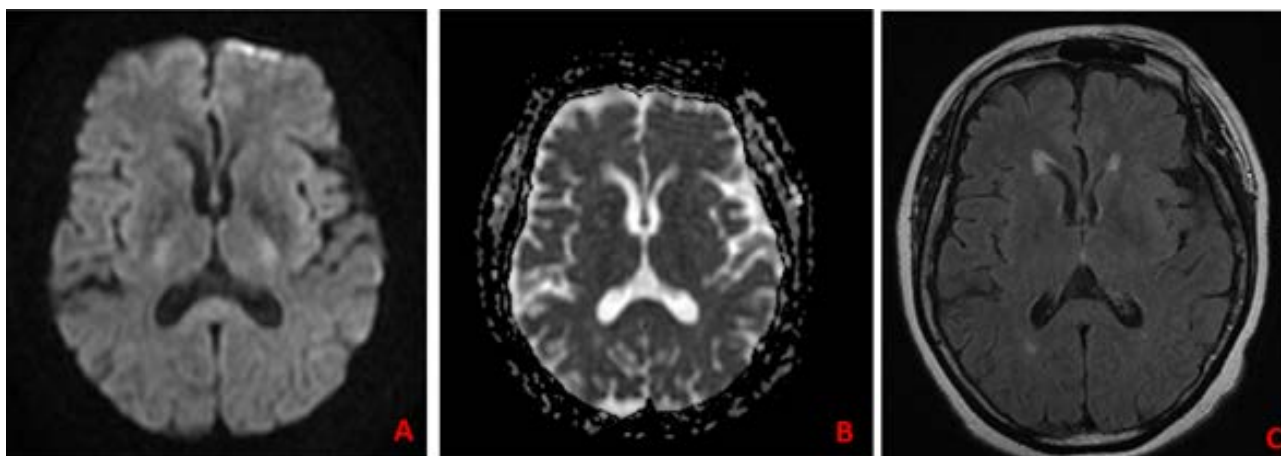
D 40 Follow-up brain MRI: (A) (diff): regression of the hypersignal of the splenium of the corpus callosum; (B) (ADC): no abnormality; (C) (FLAIR): no signal abnormality
